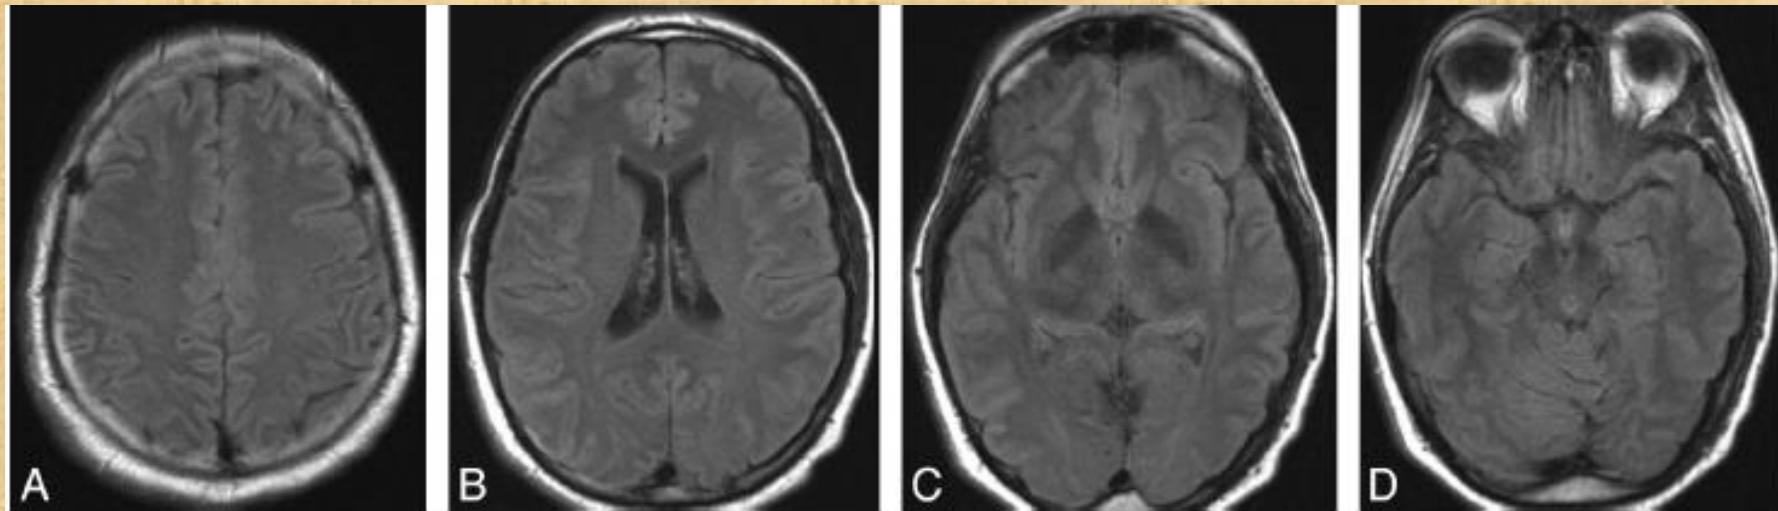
Follow-up FLAIR images after a gluten-free diet show the evolution of signal-intensity abnormalities.
